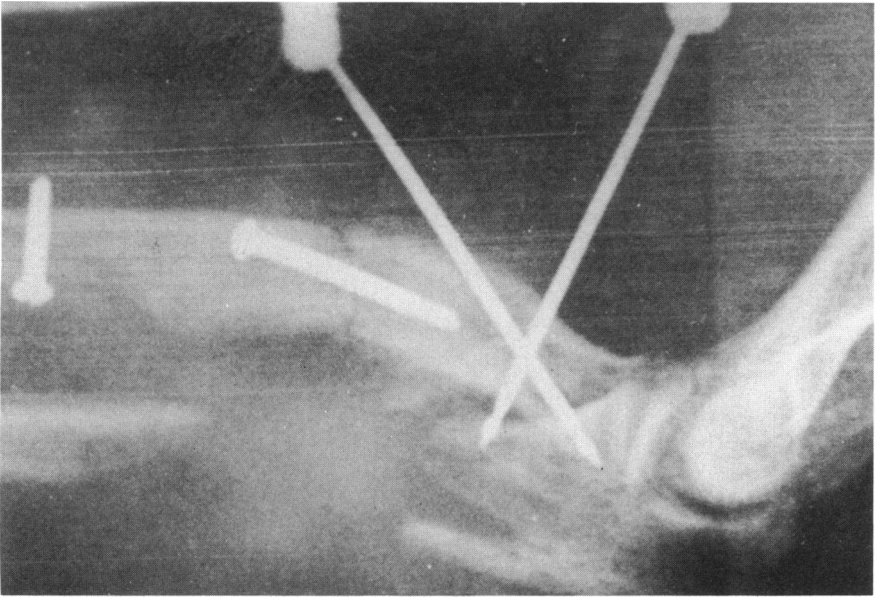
Roentgenogram showing restoration of radial length and external fixation in place.
